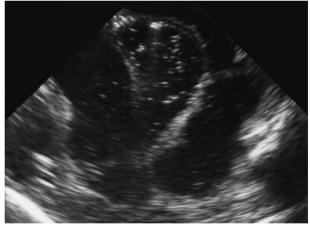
a Neonate with cystic fibrosis. Sonography shows intestinal loops filled with hyperechogenic and thick meconium. b Neonate with ileal atresia. Intestinal loops are filled with hypoechoic fluid and air
